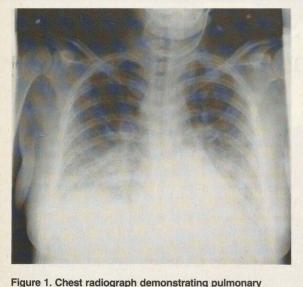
Chest radiograph demonstrating pulmonary edema.
